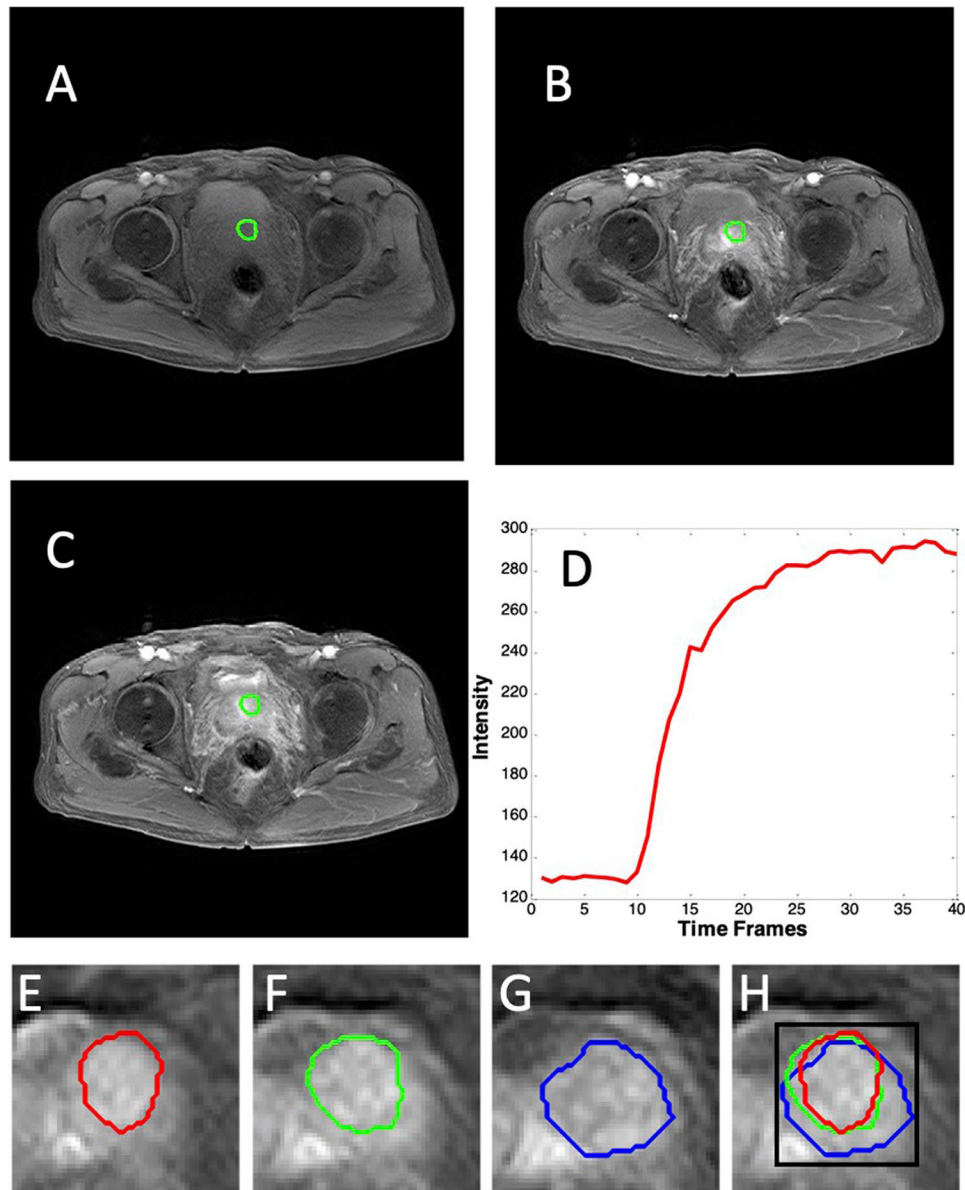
A case example of a 72-year-old man with benign prostatic hyperplasia (tPSA = 10.8 ng/mL). The suspicious lesion is manually outlined. A The first DCE-MRI time frame (pre-contrast image); B the 15th time frame post-contrast image; C the 40th time frame post-contrast image; D the DCE-MRI time-intensity curve shows the persistent enhancing pattern. E, F, G The tumor ROIs drawn on 3 consecutive slices; H the projection of 3 tumor ROIs, and the square smallest bounding box to cover the outer boundary
